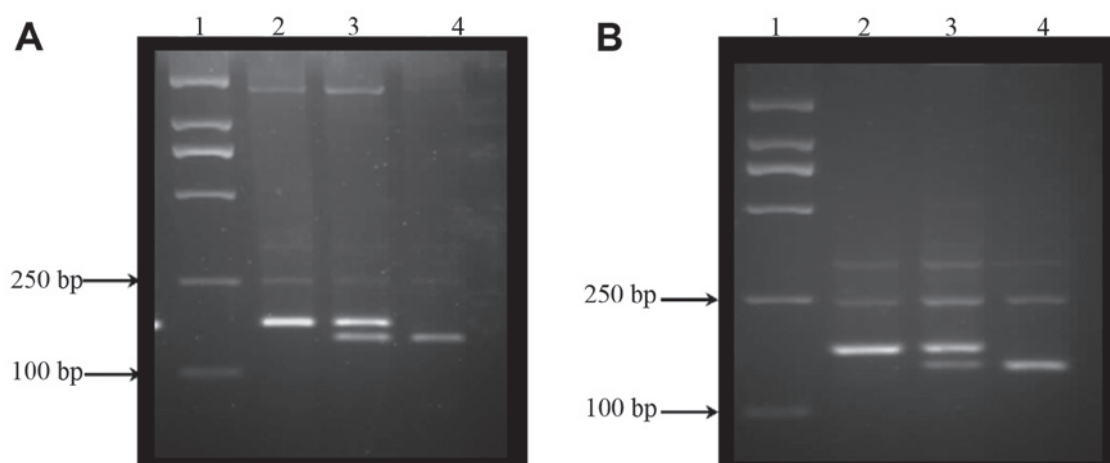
Genotyping patterns of rs1478605 and rs3743125. (A) rs1478605. Lane 1, DNA marker; lane 2, TT genotype [152 base pairs (bp) only]; lane 3, CT genotype (152+132+20 bp); lane 4, CC genotype (132+20 bp). (B) rs3743125: lane 1, DNA marker; lane 2, TT genotype (168 bp only); lane 3, CT genotype (168+145+23 bp); lane 4, CC genotype (145+23 bp).
